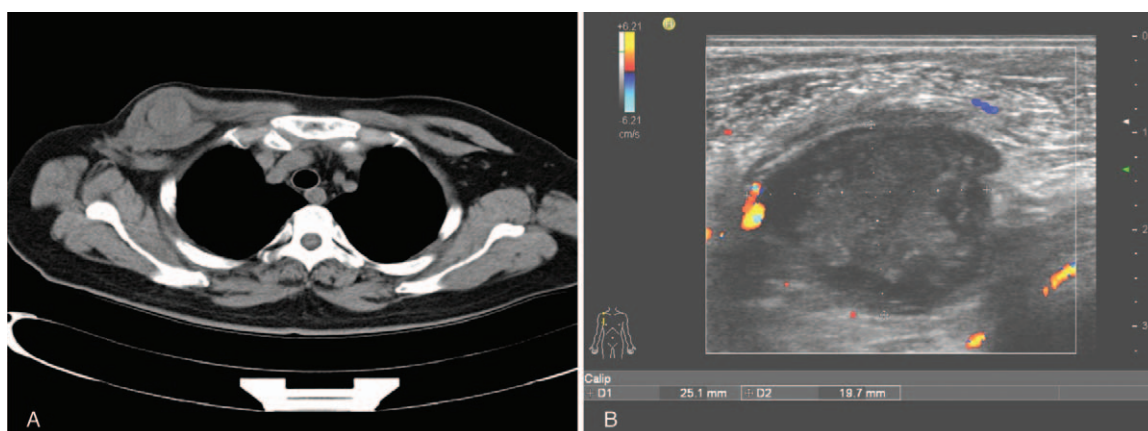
Images of the new tumor. A, A round mass with soft tissue density was noted between the pectoralis major and minor muscles on CT. B, The tumor was irregular, well circumscribed, and lobulated on sonography. CT = computed tomography.
